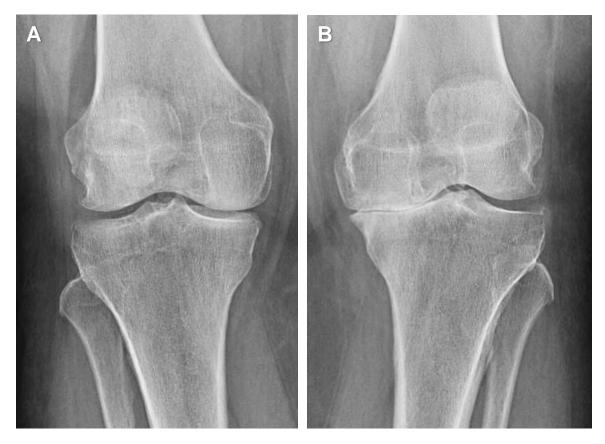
Radiographs of a normal (A) and an osteoarthritic (B) knee. The distance between the femur and tibia in the medial portion of the osteoarthritic knee is smaller than the healthy knee due to articular cartilage degradation.
